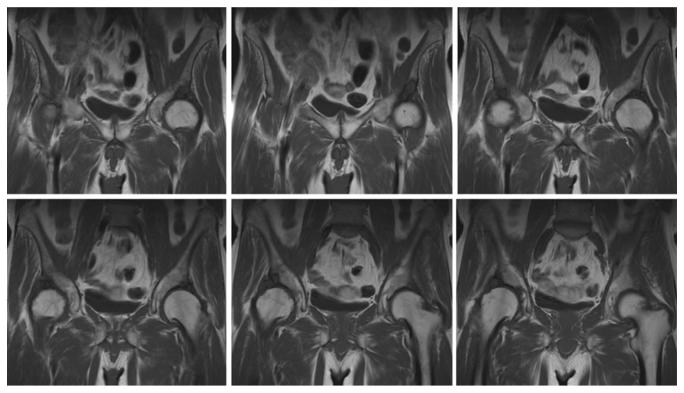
Coronal T1-weighted images; Osteoarthritis of both hips with marginal osteophytes of the acetabular roof, of the front and rear acetabular pillars and of the femoral neck. Multiple subchondral geodes on the anterolateral side of the acetabular roof. Bilateral reduction of the front, top and medial joint space with moderate joint effusion on the right.
